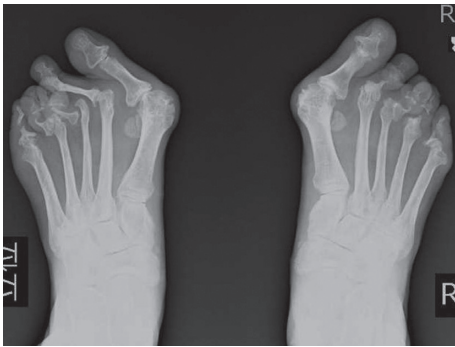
Plain radiographs of the feet.
